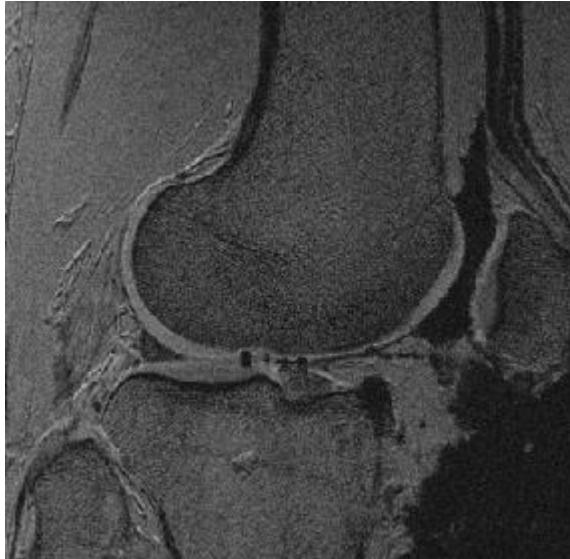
A sample MRI scan of the right knee joint
